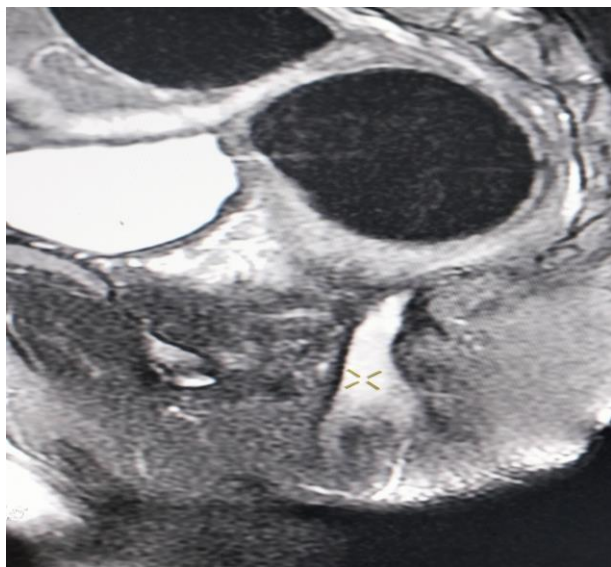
Sagittal T2W FSE with fat sat MRI view of the index patient showing 6.9cm long hyperintense perianal fistulous tract with maximum thickness of about 4.5mm extending from the left perianal skin along the gluteal cleft about just 1.5cm and just anterior to the anal verge.
